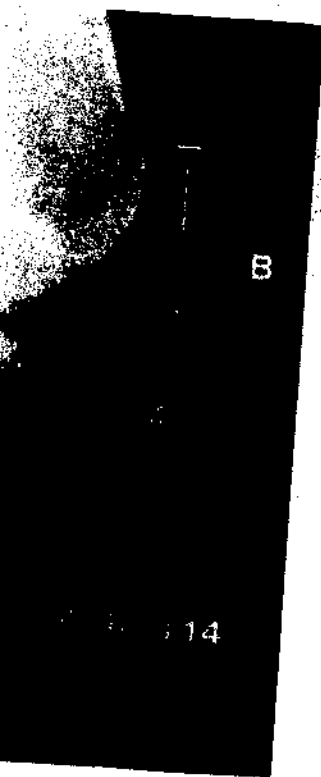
AND 2B. (A) Lateral radiograph of the knee before surgery. (B) Lateral radiograph of the knee after surgery, demonstrating patella baja.
